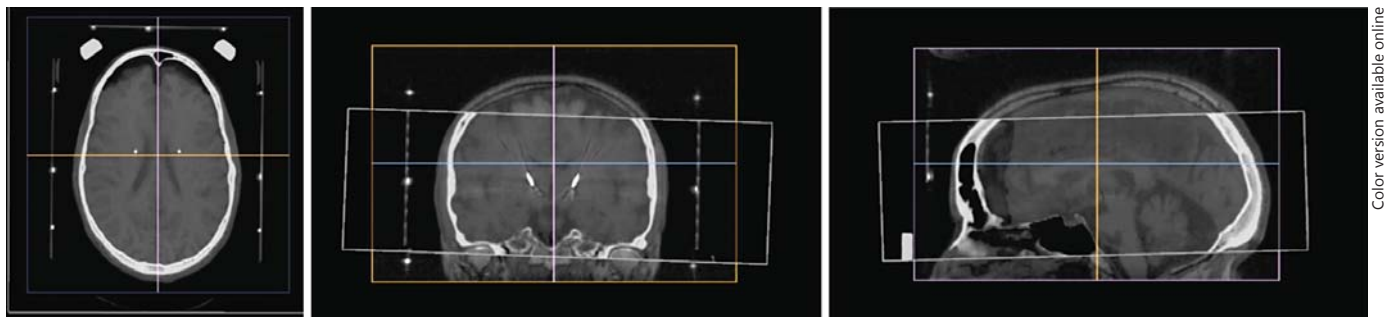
Neuroinspire screenshot of a preoperative T₁ MR image fused to a CT image of the head after electrode insertion. Axial, coronal and sagittal views are demonstrated.
